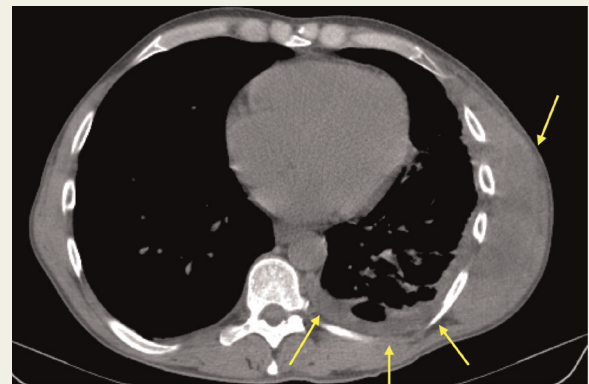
Initial non-contrast CT showing haematoma along chest wall with empyema.
